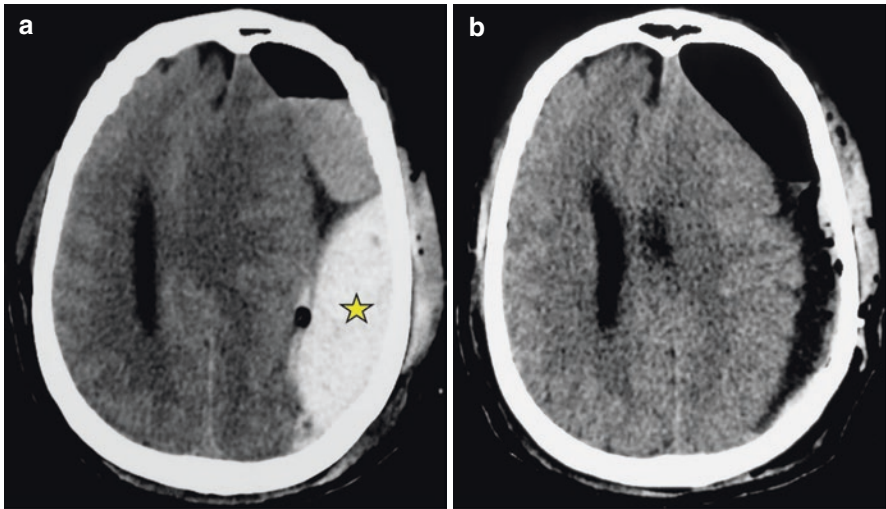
Immediate postoperative acute extradural hematoma (star) following burr holes evacuation of a chronic subdural hematoma. The patient was reoperated urgently through a bone flap craniotomy with a good outcome. Immediate postoperative CT scan (a) and following the second surgery (b)
